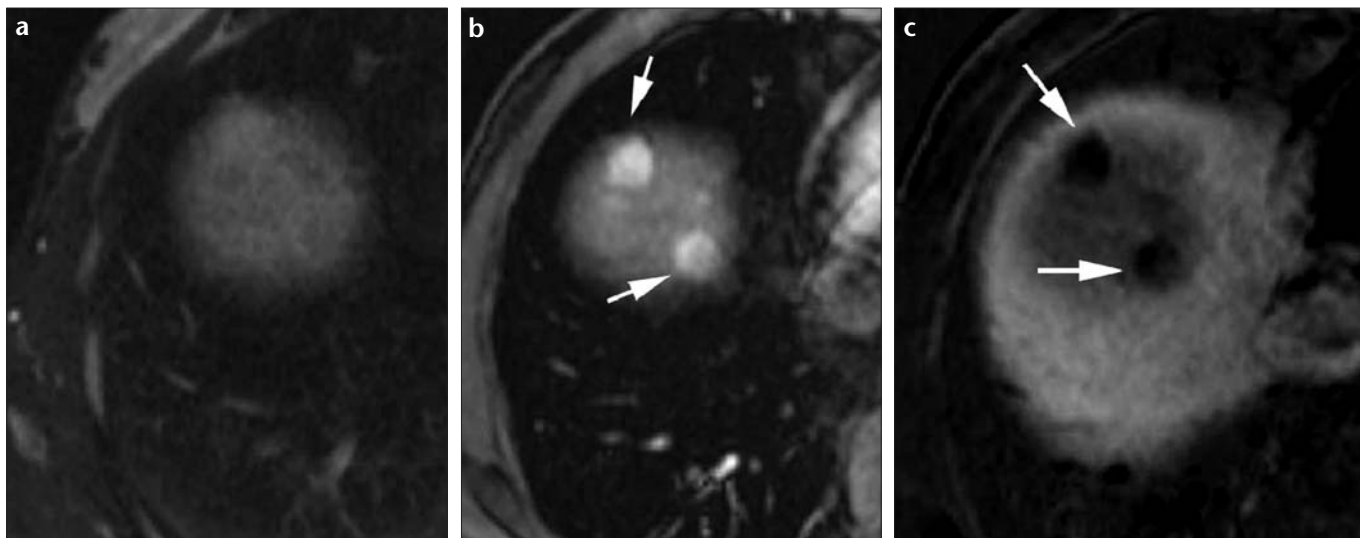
a-c. Hepatocellular carcinoma occurring in a cirrhotic liver. Transverse fat-saturated TSE T2-weighted MR image (a) shows no visible lesion. Two hyperintense lesions in the subdiaphragmatic area (arrows) show hypovascular nature in the arterial phase on both the T1-weighted MR image without contrast agent (b) and the subtraction image (c) performed for detecting the vascularity of these hyperintense lesions. These two lesions were diagnosed as dysplastic nodules by both radiologists.
